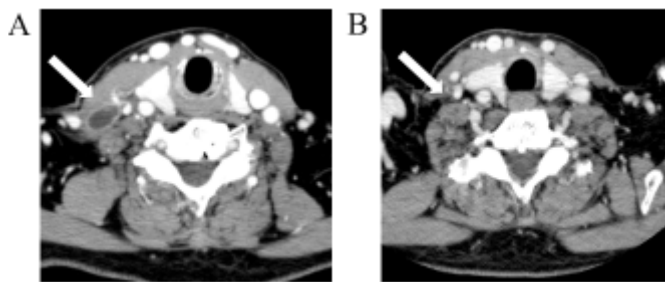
Contrast-enhanced computed tomography (e-CT) image 3 months after the start of administration showing that the metastatic lymph nodes are clearly reduced (A, arrow). Seven months after the start of administration, an e-CT image showing that the metastatic lymph nodes have disappeared (B, arrow).
